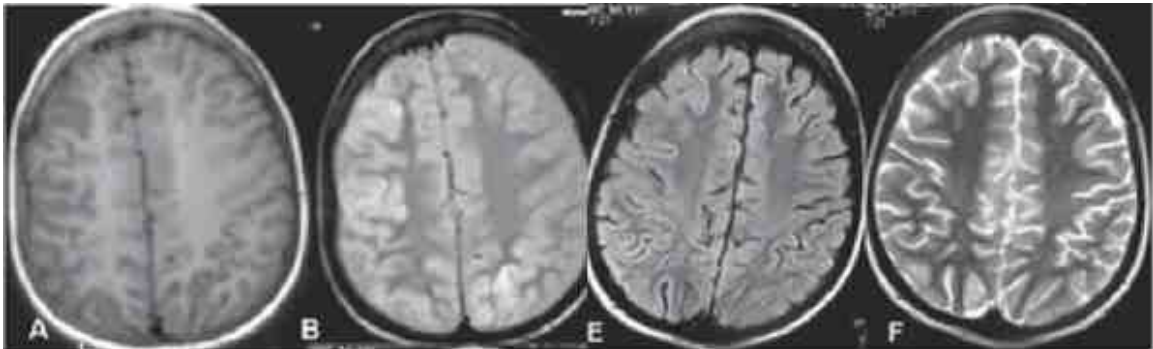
Samples of four MRI images: (A)T1-weighted, (B)PD, (E)FLAIR, and (F)T2 weighted axial brain images
